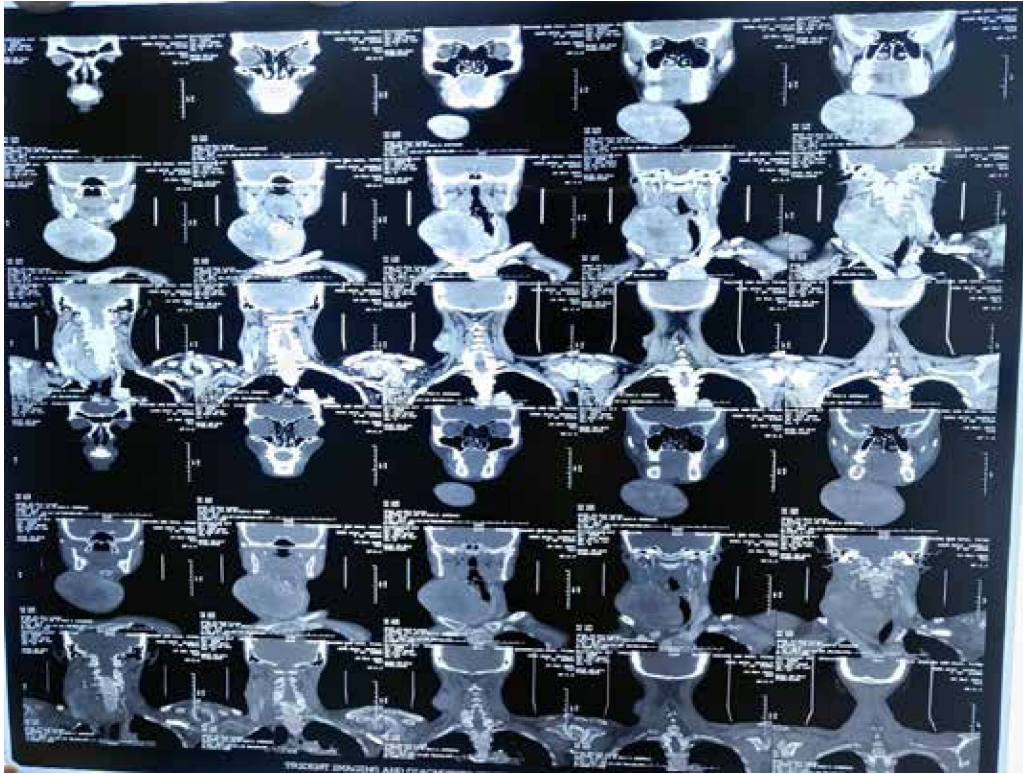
Contrast-enhanced CT scan of the neck showing massive thyroid enlargement with significant tracheal deviation and compression
